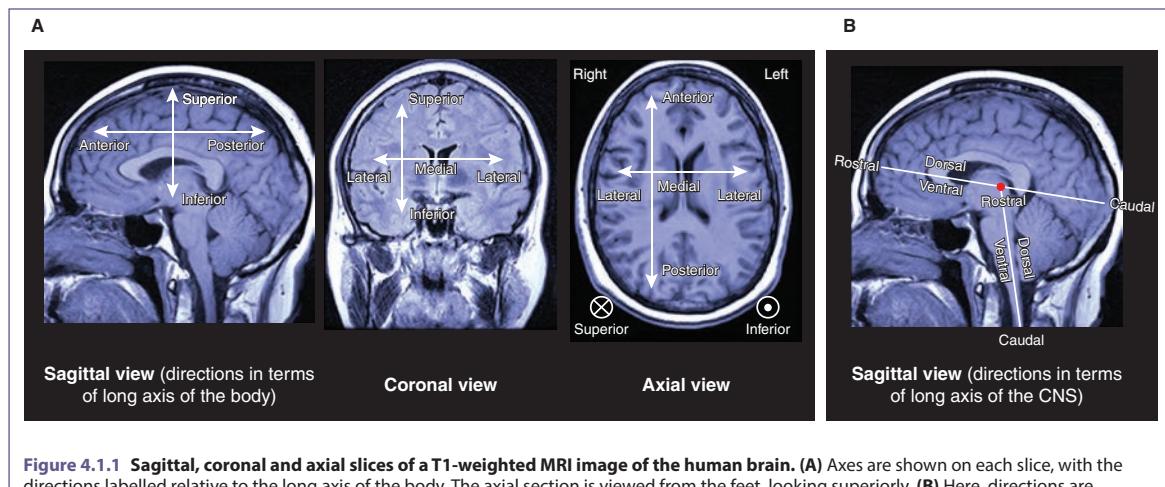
Sagittal, coronal and axial slices of a T1-weighted MRI image of the human brain. (A) Axes are shown on each slice, with the directions labelled relative to the long axis of the body. The axial section is viewed from the feet, looking superiorly. (B) Here, directions are labelled relative to the long axis of the CNS, which bends at the cephalic flexure (red dot). The rostral direction is sometimes referred to as 'cranial'.
